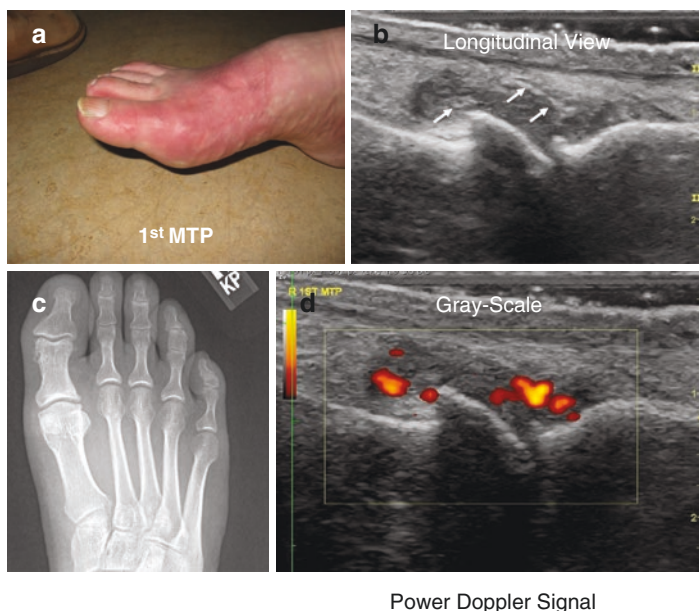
Case 1. (a) Erythema over the first MTP in a patient with PODAGRA. (b) X-rays of the foot with minimal soft-tissue swelling. (c) Point-of-care ultrasound with a longitudinal view of the 1st MTP showing hyperechoic aggregates (arrows) within the joint capsule. (d) Inflammation with positive power-Doppler signal within the joint capsule consistent with inflammatory arthritis on ultrasound
